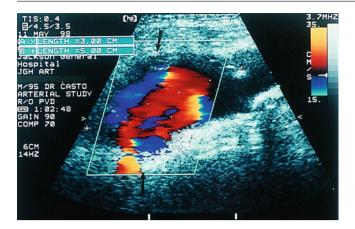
A color duplex ultrasound image of the same patient as in Fig. 35.11a showing another aneurysm of the left common femoral artery that measures 5 cm in length and 3 cm in AP view (*arrows*)
